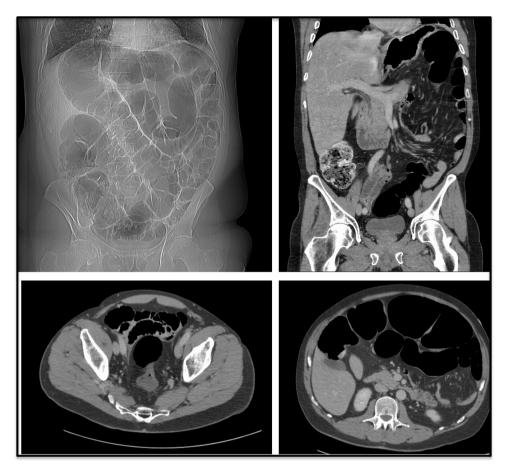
Initial computed tomography (CT) abdomen and pelvis scan findings on patient presentation.
